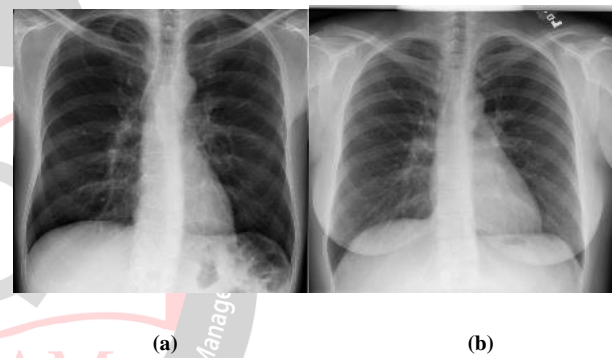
X-Ray of Healthy Patient (a) vs X-ray of Covid-19 Positive Patient (b).
